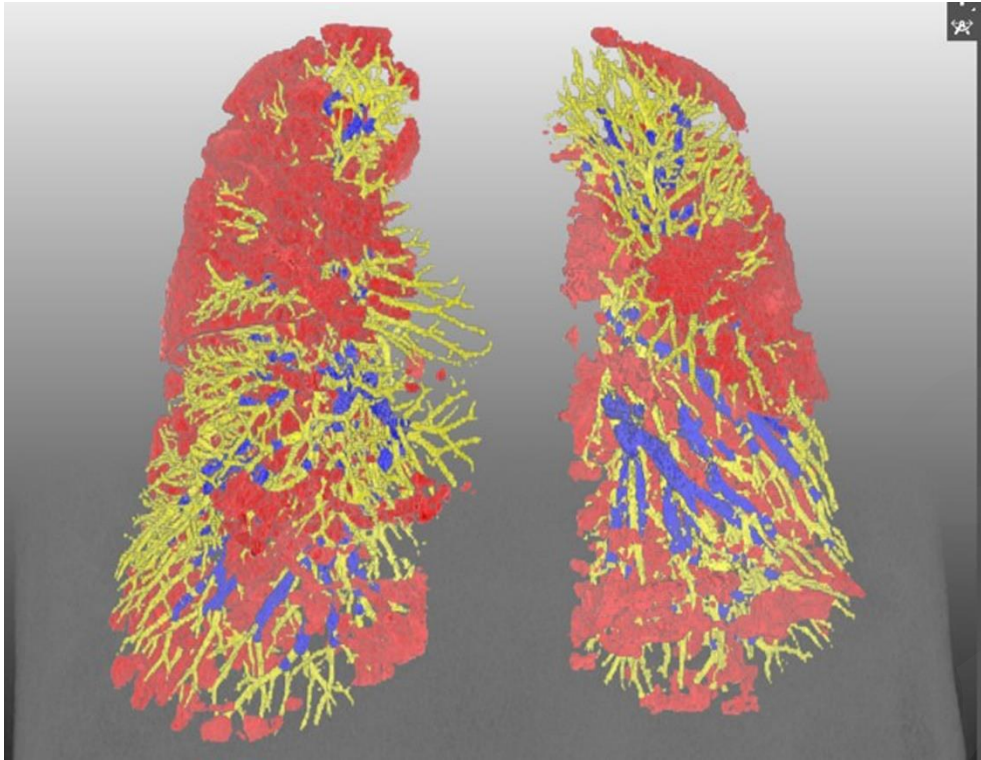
Chest CT from a 52-year-old male with the Omicron variant.
